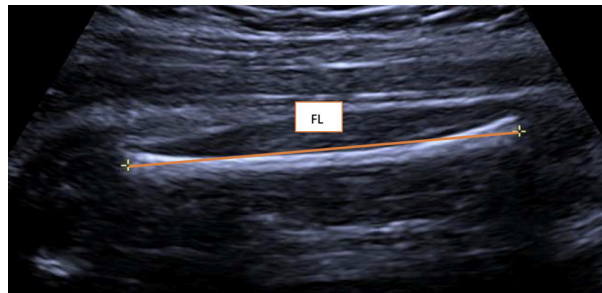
FL measurement by ultrasound (78)
